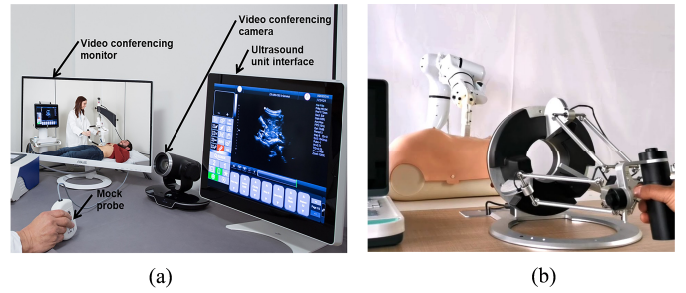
Two typical teleoperation interfaces for robot-assisted tele-sonography. (a) is a probe-like teleoperation device without haptic feedback. (b) is a customised teleoperation interface with haptic feedback.
